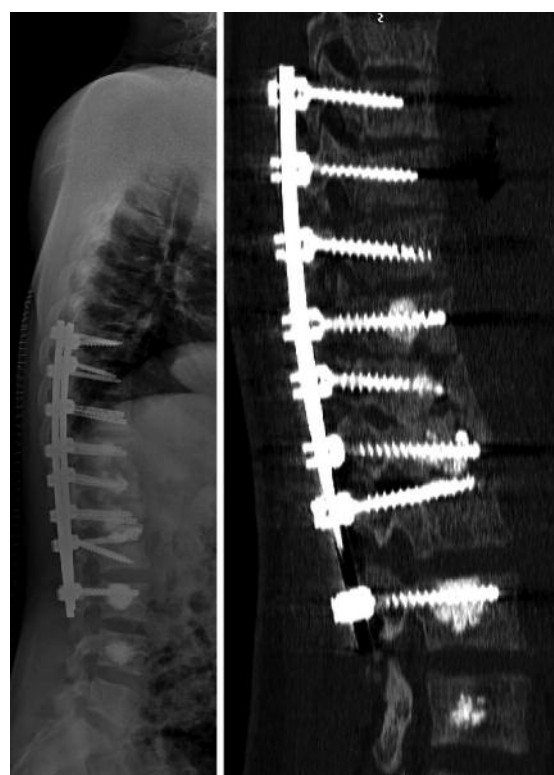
Lateral X-ray and sagittal CT scan performed after the second surgery, showing the revision arthrodesis T8-L3 and vertebroplasty in T4.
